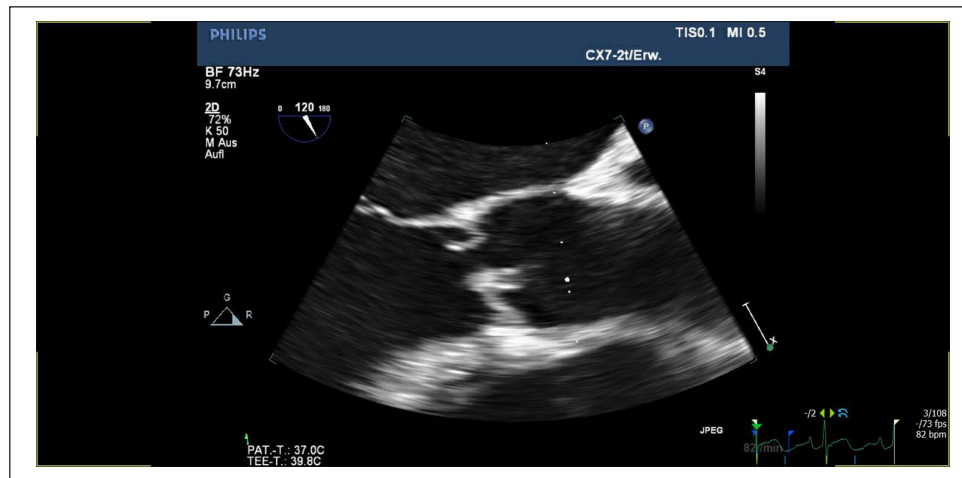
Transesophageal echocardiography (TEE) midesophageal aortic valve long-axis view showing aortic valve endocarditis with perforated cusp and severe aortic regurgitation.
